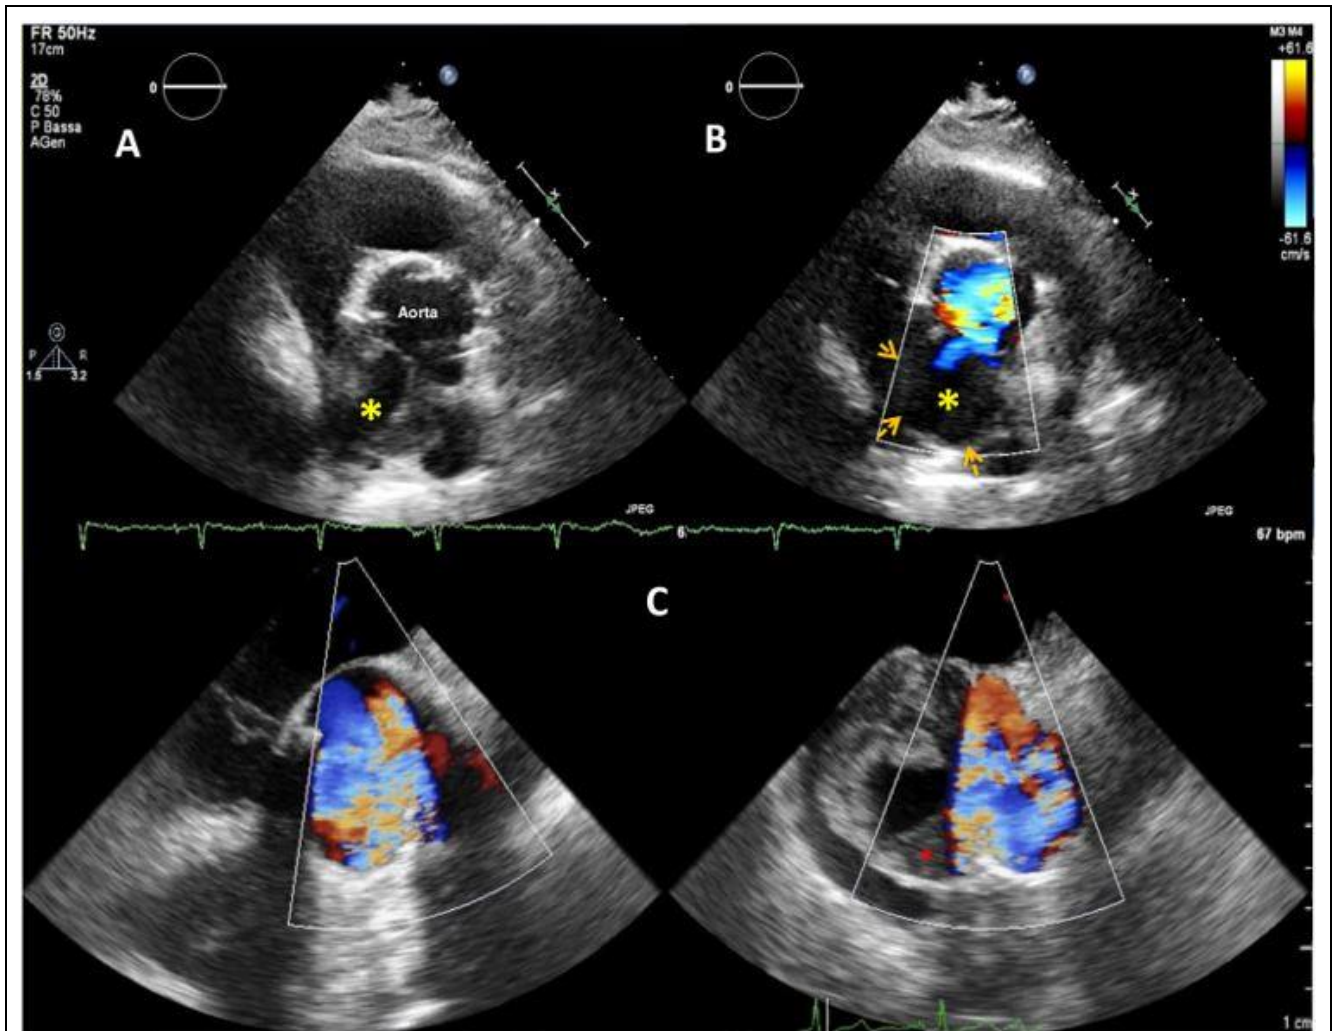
2D TEE middle esophageal short axis view of aortic root showing the ostium of a giant ARPA (yellow star), originating from non coronary sinus of Valsalva (A) and color flow inside ARPA (borders outlined by orange small arrows) in the systolic frame (B); 3D TEE color Doppler X-plane rendering middle esophageal view showing the giant ARPA with thrombotic apposition (red star) and color flow inside aortic root and ARPA ostium.
